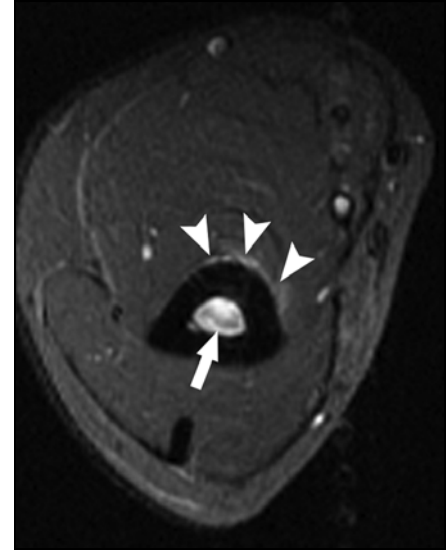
24-year-old male professional tennis player with distal humeral stress reaction. Axial STIR MR image shows entire marrow cavity is of high signal intensity (*arrow*). Anteromedial periostitis (*arrowheads*) is evident.
